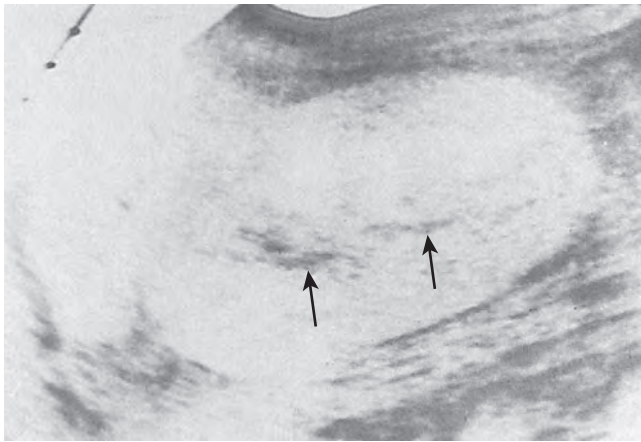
Acute pyelonephritis. Ultrasound image of the right kidney demonstrates renal enlargement, hypoechoic parenchyma, and compressed central collecting complex (arrows). (From Schaeffer AJ. Urinary tract infections. In: Gillenwater JT, Grayhack JT, Howards SS, et al, editors. *Adult and pediatric urology*. Philadelphia: Lippincott William & Wilkins; 2002. p. 211–72.)
